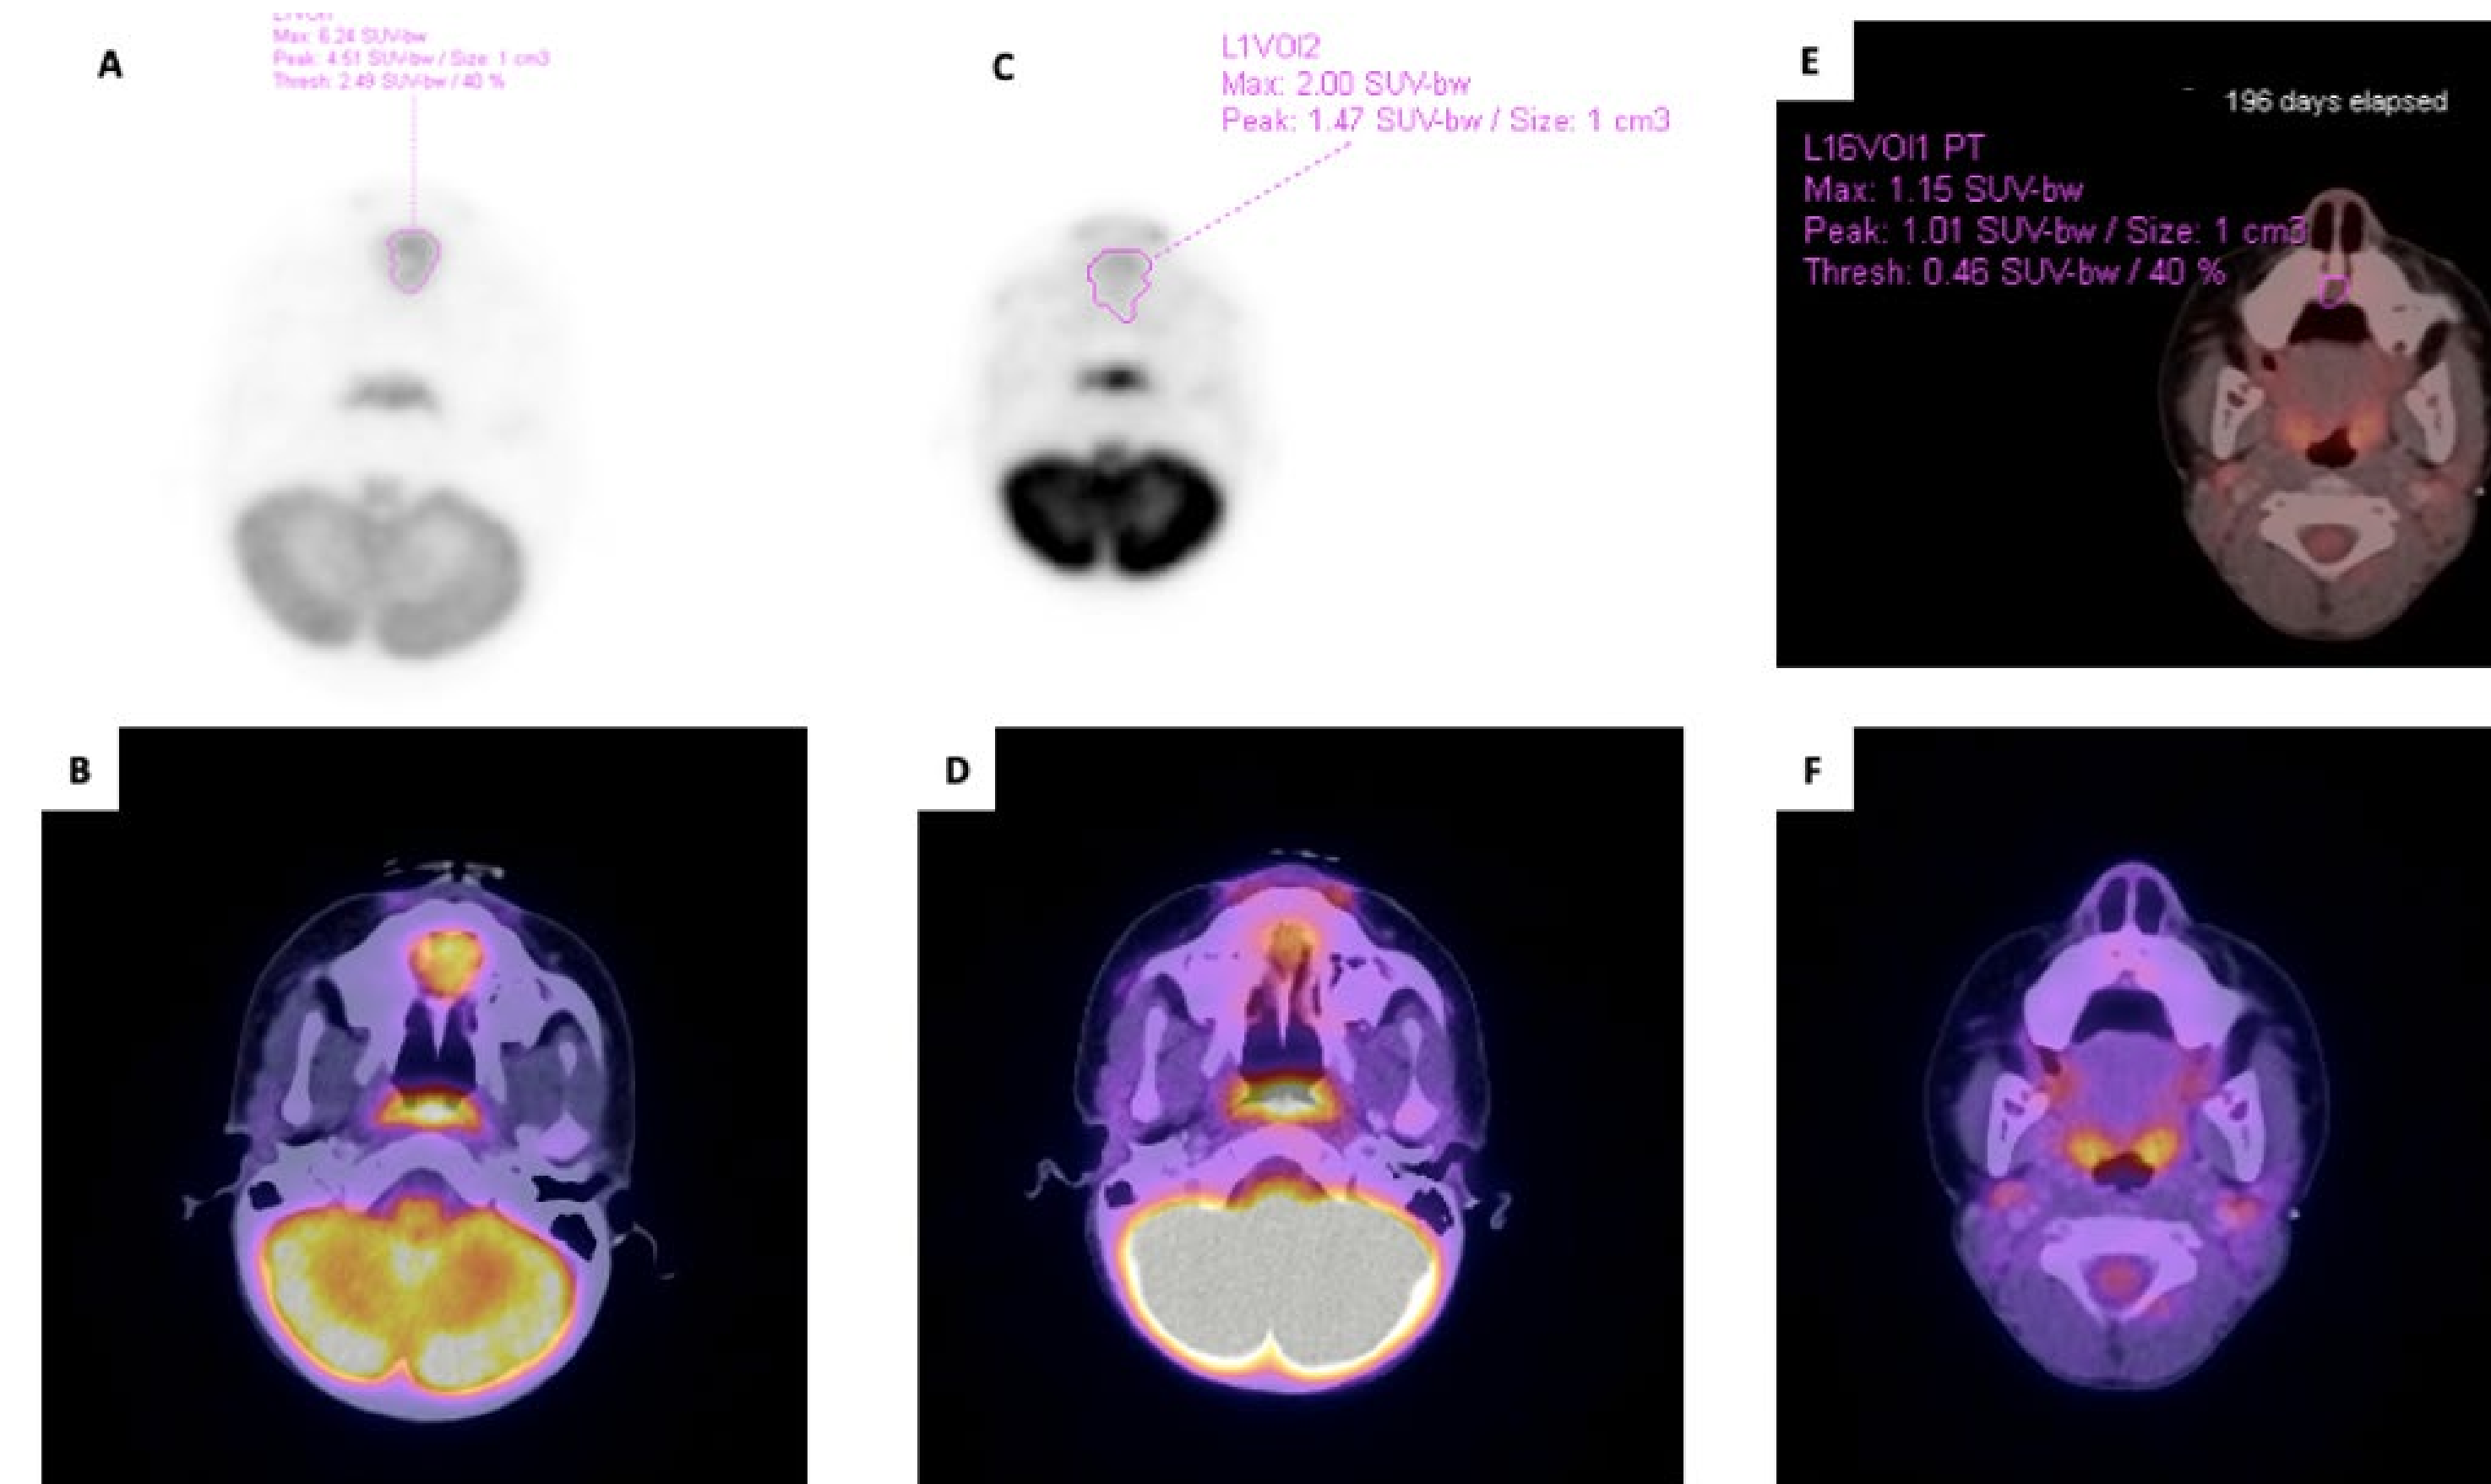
Positron emission tomography computed tomography (PET CT). A/B: Pre-treatment demonstrating FDG avidity of lesion. C/D: Approximately 1.5 months into treatment showing some decreased FDG avidity at the lesion. E/F: 6 months into treatment showing barely perceptible residual focal lucency and nearly resolved FDG avidity.
